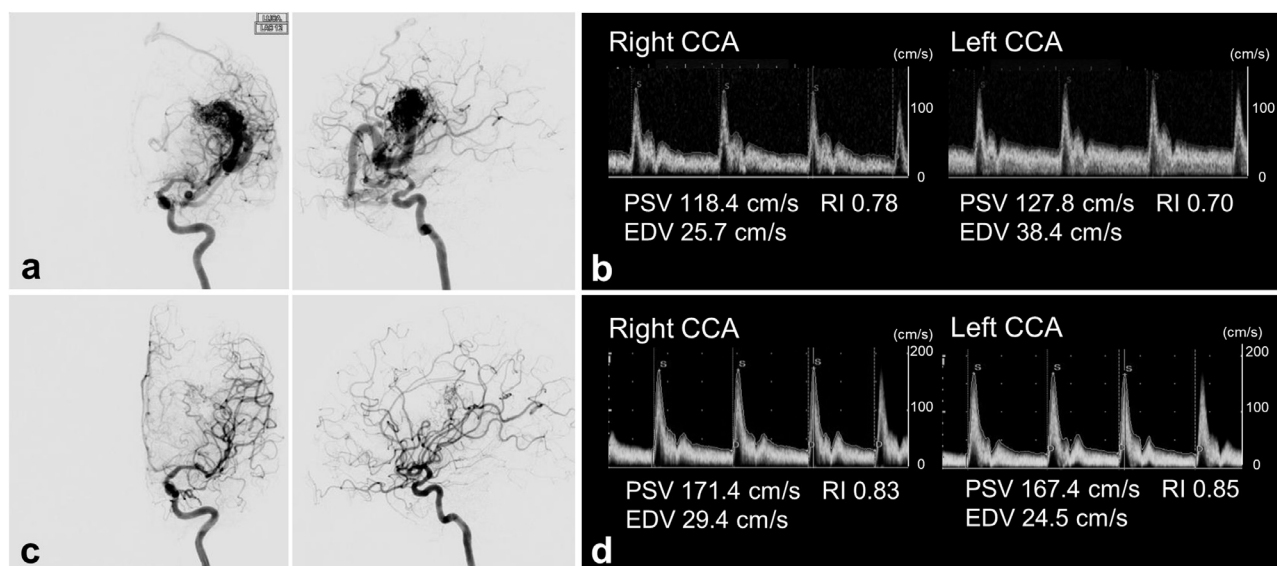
Case 2. (a) Preoperative left ICAG. Frontal (left) and lateral (right) projections show the AVM and draining veins. (b) Preoperative carotid ultrasonography shows an increased EDV in the left CCA. (c) Postoperative left ICAG. Frontal (left) and lateral (right) projections show the disappearance of most parts of the AVM. (d) The elevated EDV in the left CCA is no longer evident in postoperative carotid ultrasonography.
